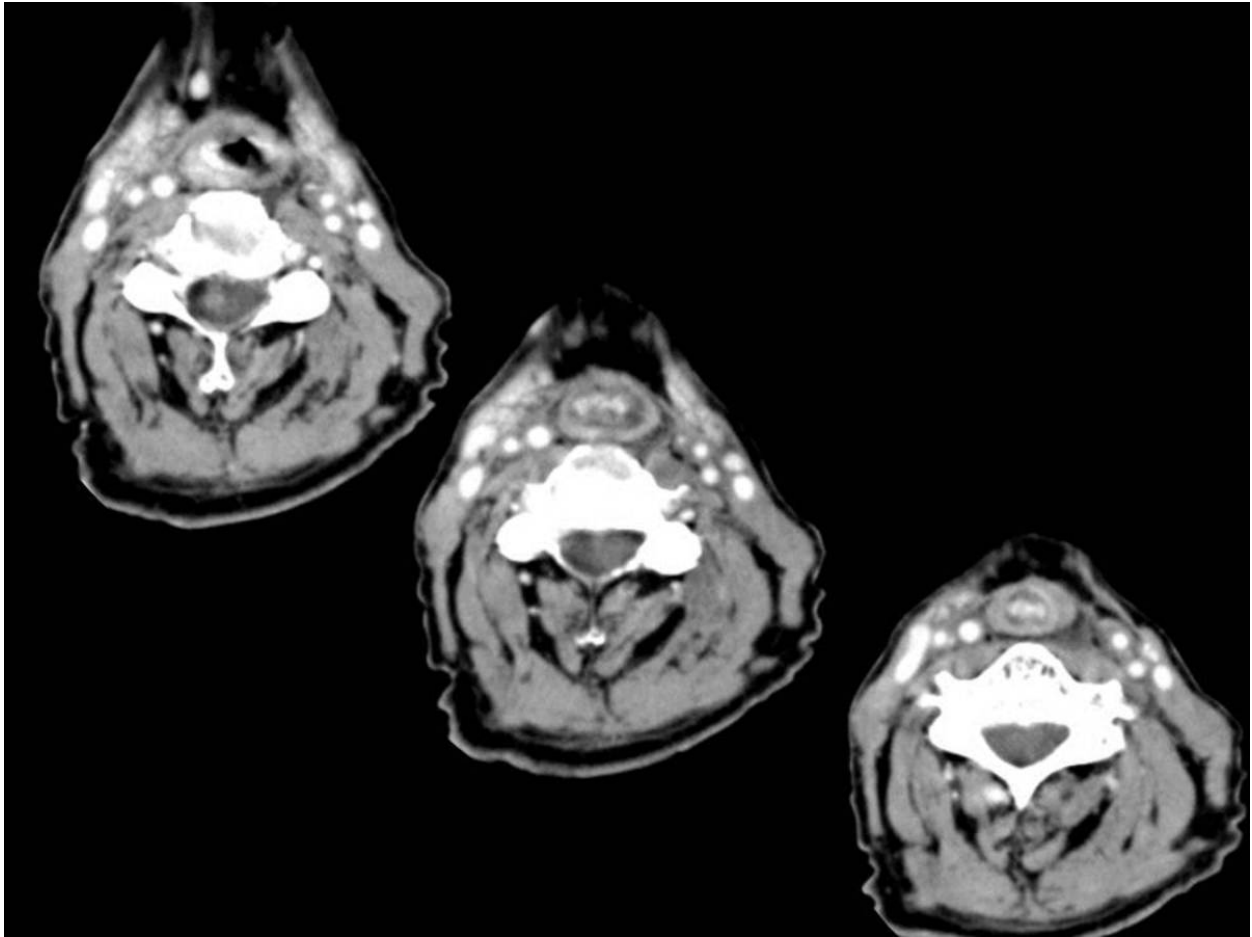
Tortuous internal carotid arteries. Same patient of Fig.8.: enhanced computed tomography - sagittal, axial and coronal views - demonstrates medial deviation of both internal carotid arteries into the retropharyngeal space.
